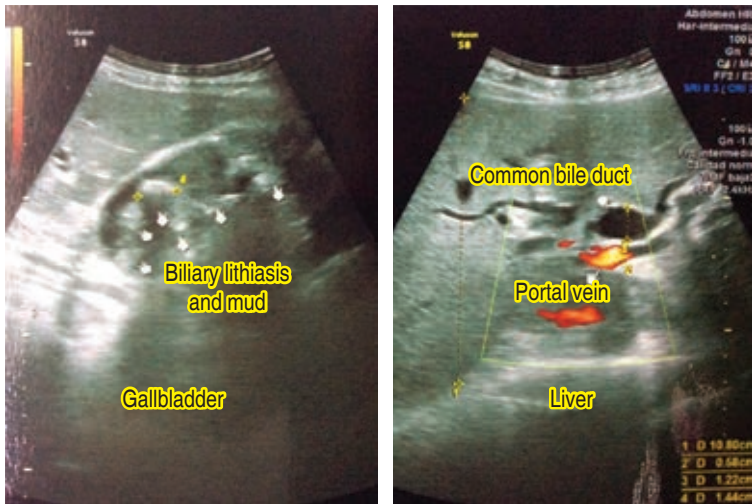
Ultrasound scan of the liver and biliary tract demonstrating dilatation of the hepatic and biliary ducts. Gallbladder with multiple lithos and biliary sludge with a common bile duct of 12 mm in diameter is shown.
